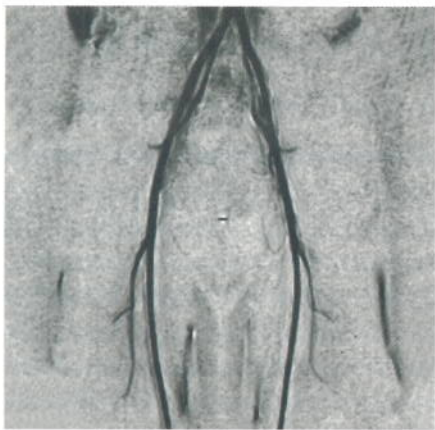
2D PCA of iliac arteries, V_{OPT} 60 cm/s, sequence used was fl2d_pc_60_60_60_8fb108.wkc, TR 80 ms, TE 8 ms, Flip 11 deg, FOV 375 mm, no RecFOV, no swap, matrix 192x256, slice thickness 100 mm, 2 acquisitions, coronal, cardiac triggered with 100 ms trigger delay and 5 phases, scan time 5+ min, MAGNETOM Vision, Body coil. The best three acquired cine images were combined (added) and filtered (F:7) and the final image was negated (black on white) for optimal presentation, but no MIP was involved. (Courtesy of N.E. Indiana MRI)
